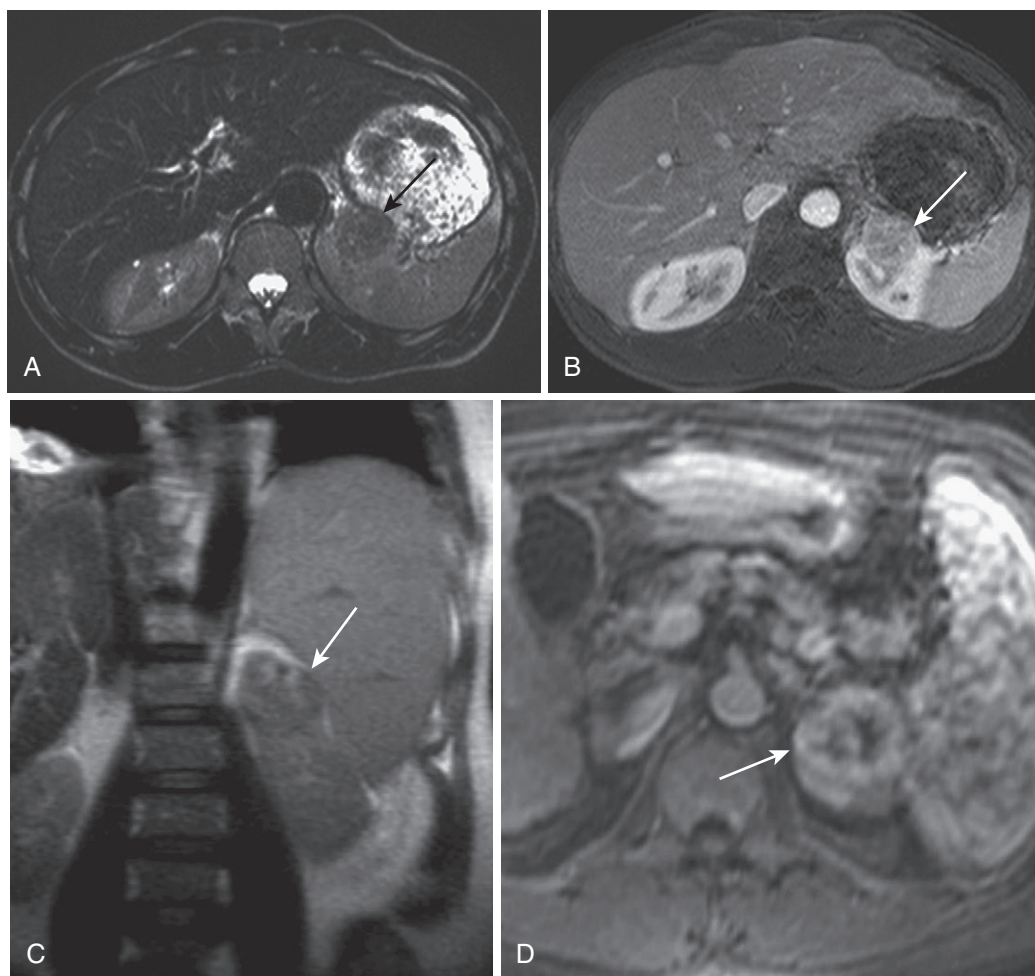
Oncocytoma. A, The axial image shows a lesion arising from the upper pole of the left kidney (*arrow*), which is hypointense relative to the typical T2 appearance of oncocytoma. B, The corresponding arterial phase image shows a radiating enhancement pattern (*arrow*), faintly reminiscent of the classic “spoke-wheel” pattern. The coronal T2-weighted image (C) in a different patient shows an exophytic lesion (*arrow*), intensely enhancing in a loose “spoke-wheel” fashion on the arterial phase image (D).
